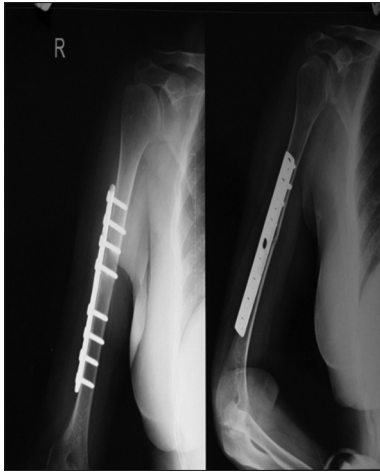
Case 2 - 12 weeks post-operative X-ray
